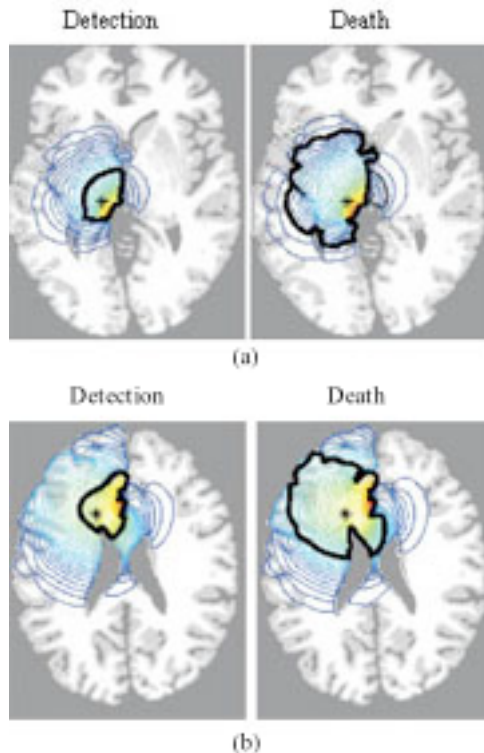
Computed solutions of equation (1) in a three dimensional anatomically accurate brain. These show the horizontal section of the virtual human brain through the site of the original tumour (+ in (a), * in (b)). The left image in each is the tumour at diagnosis while the right image is the same tumour at time of death. The thick black contour defines the edge of the tumour that can be detected by enhanced CT. The blue contours outside this black line represent cancer cell densities peripheral to the imaging limits. (a) Tumour in grey matter: the time from diagnosis to death is approximately 256 days. (b) Tumour in white matter: the time from diagnosis to death is approximately 158 days. (Figures extracted from Swanson *et al.* 2002a).
